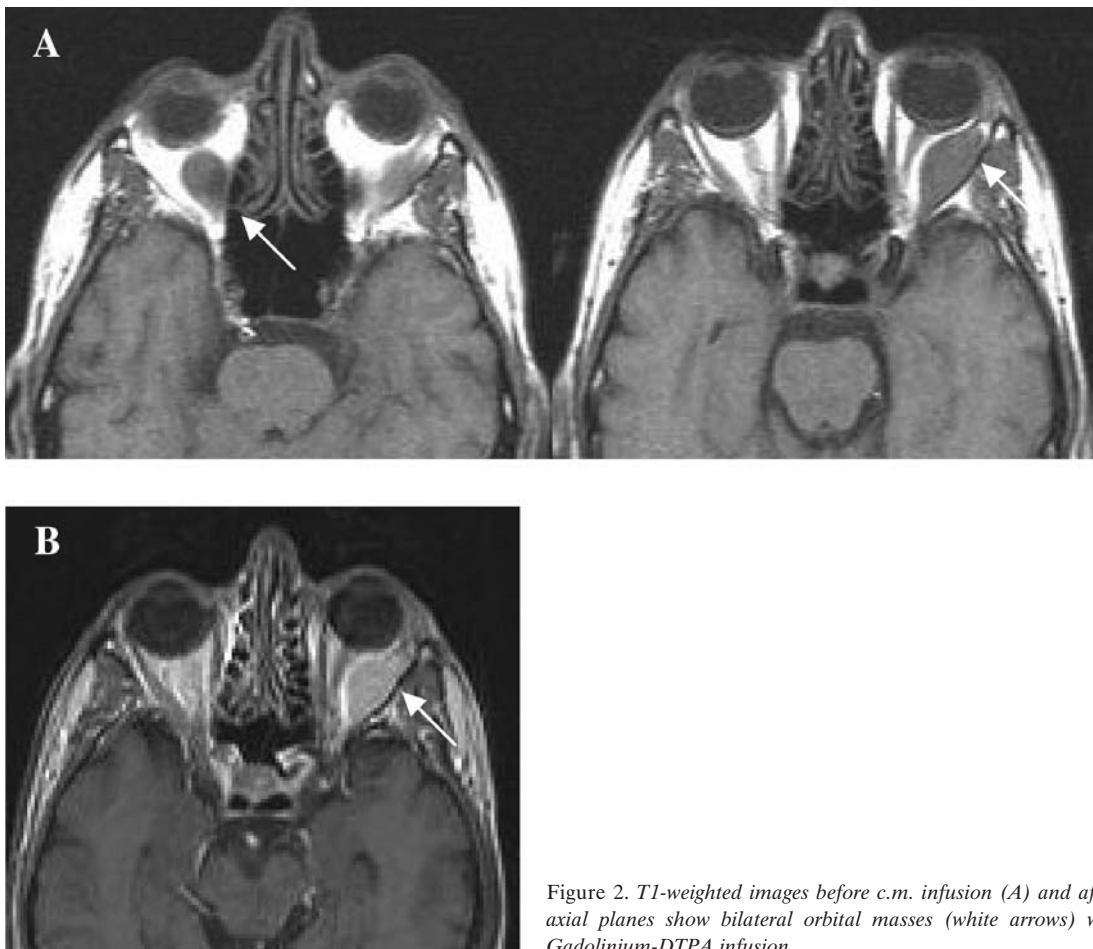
T1-weighted images before c.m. infusion (A) and after c.m. infusion (B) in axial planes show bilateral orbital masses (white arrows) with enhancement after Gadolinium-DTPA infusion.
